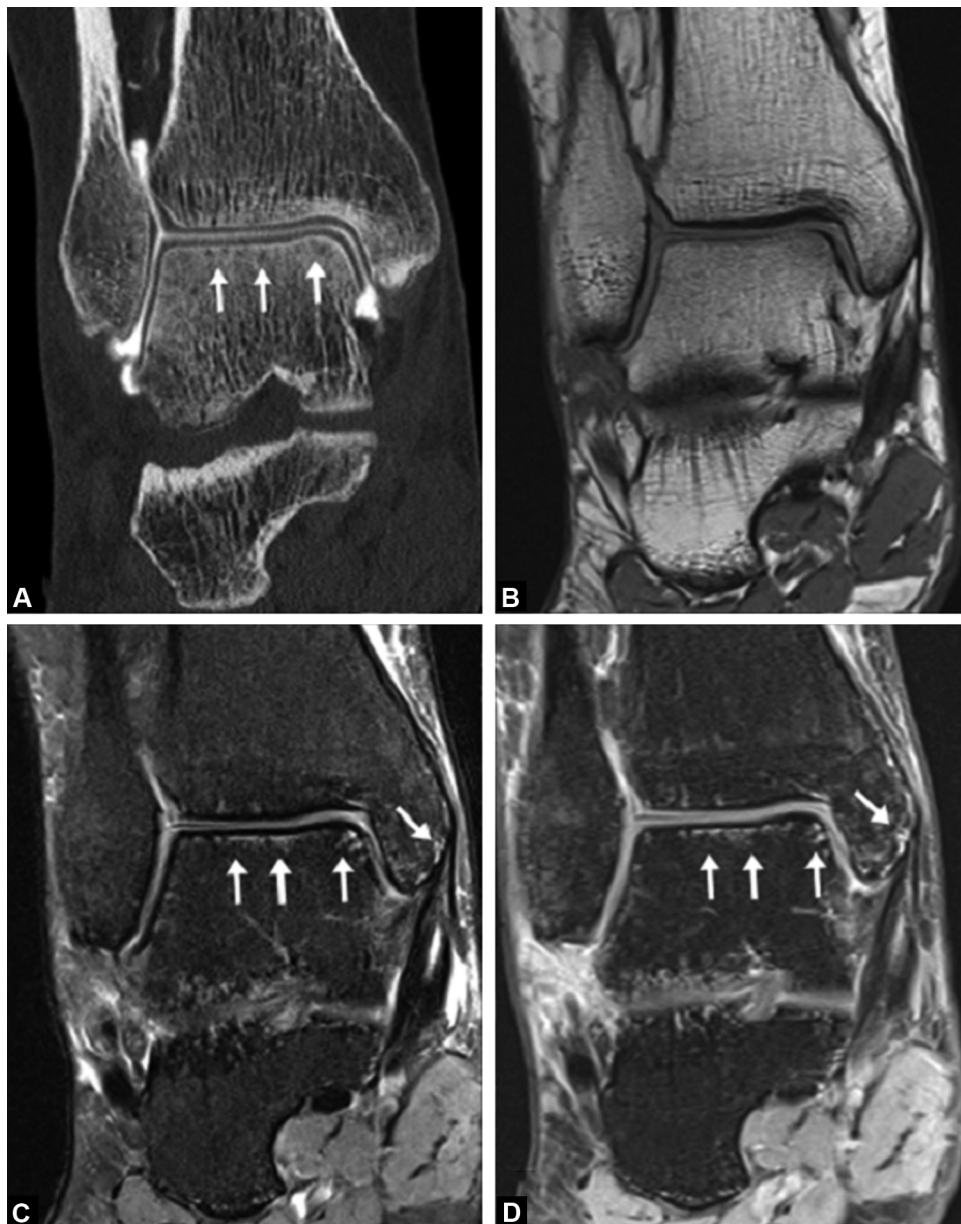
Regional osteopenia in a 40-year-old woman 12 weeks after right lateral ankle sprain. (a) CT image of the right ankle in the coronal plane demonstrates subcortical bone resorption (arrows). (b) T1-weighted spin-echo image in the coronal plane (TR/TE, 520/18 msec) demonstrates normal marrow signal intensity. (c) Corresponding fat-saturated intermediate-weighted image (TR/TE; 4370/42 msec) demonstrates subcortical linear areas of high signal intensity (arrows). (d) T1-weighted Dixon water-only image (TR/TE, 862/12 msec) obtained after intravenous administration of a gadolinium-based contrast agent demonstrates increased signal intensity in the same areas as in (c) (arrows).
